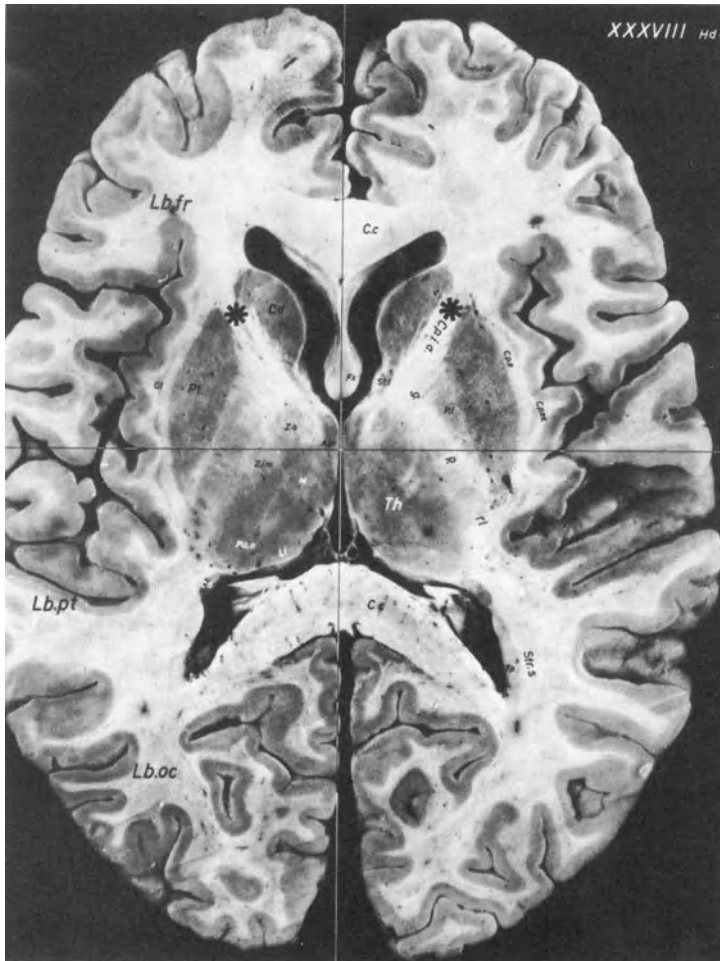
Axial CT image at the level of the foramen of Monro. Arrows indicate recommended target sites in the anterior limbs of the internal capsules (A). Corresponding section of a brain; target sites are marked by asterisks (B). (From Schaltenbrand G, Bailey P [eds]: *Introduction to Stereotaxis with an Atlas of the Human Brain*. New York: Grune and Stratton, 1959.)
